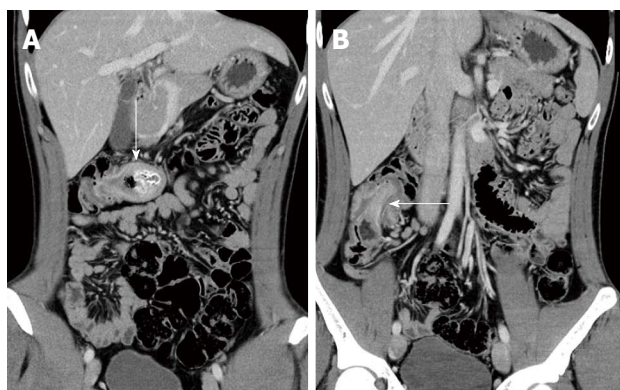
Coronal computed tomography of the abdomen. A: A cystic lesion 4 cm in diameter in the transverse colon (arrow). The lesion contained stool-like material and acted as a lead point for intussusception; B: Intussusception of the right colon (arrow).
